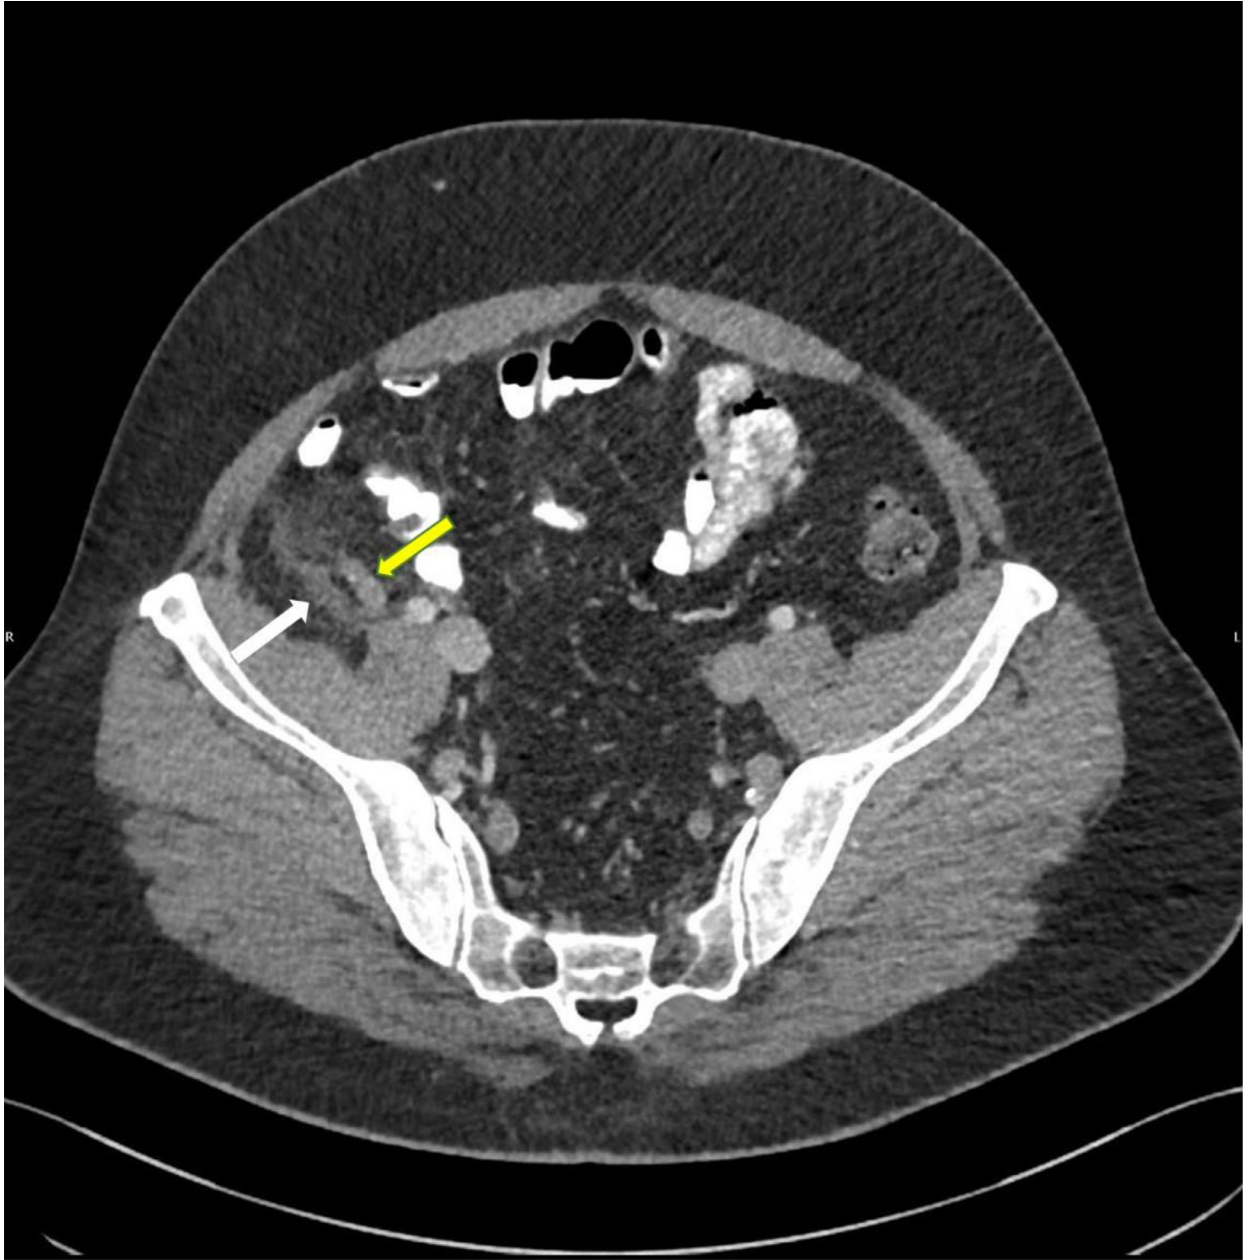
Axial contrast CT image of the abdomen in the venous phase demonstrates normal appendix (yellow arrow). Fat stranding (white arrow) is seen adjacent to the appendix.
